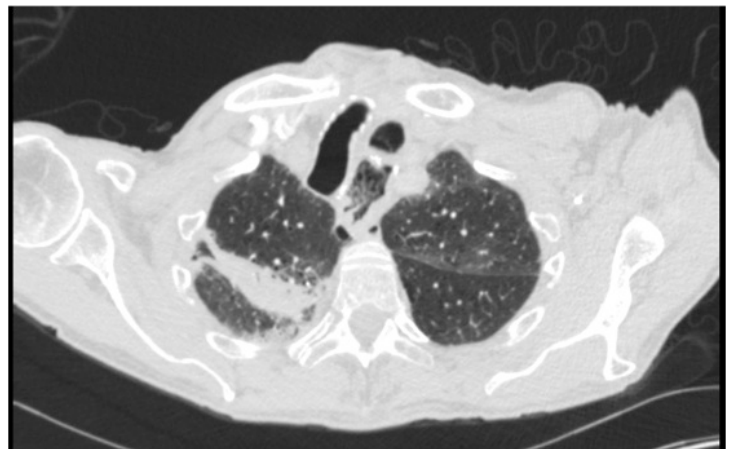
Computed tomography shows a RUL consolidation consistent with pneumonia and altered tracheal/esophageal anatomy secondary to severe kyphosis. The study also shows LLL consolidation at another level not seen here.
